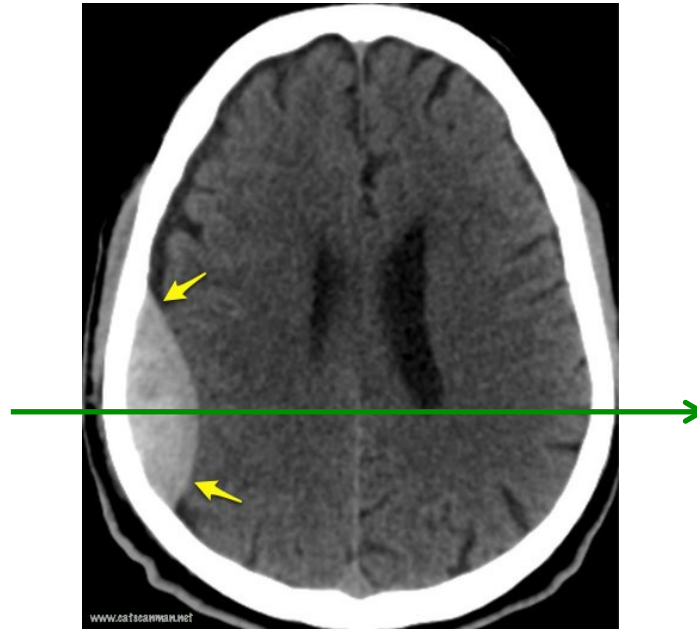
Figure #3: CT image of an *epidural hematoma*.
